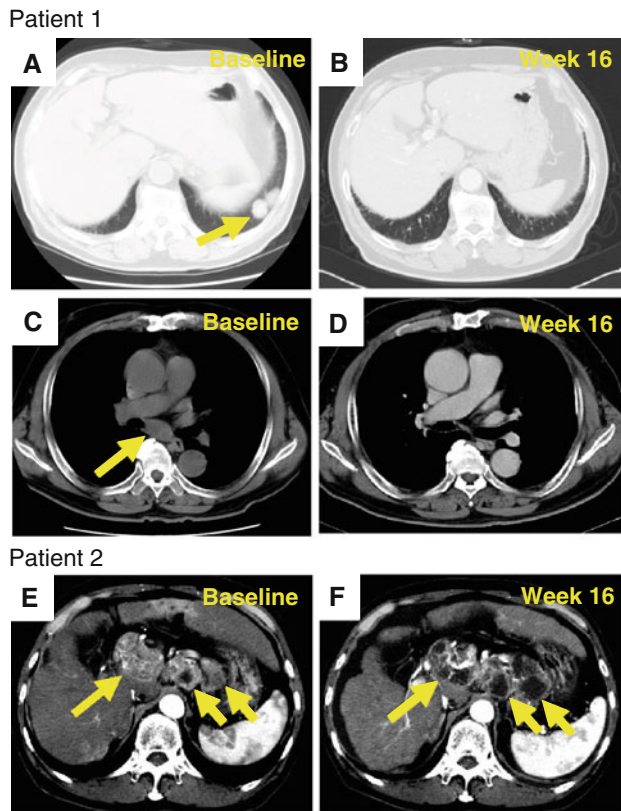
Computed tomography images of responding lesions from patient 1, who achieved a complete response. Metastatic lesions in the lung (a) and lymph node (c) disappeared after four cycles (16 weeks) of TSU-68 treatment (b, d). Representative computed tomography images of a tumor showing necrosis in patient 2. Before treatment, several abdominal lymph node metastases were apparent (e). After four cycles of treatment (16 weeks), the lesions demonstrated a lack of enhancement and markedly lower attenuation, consistent with tumor necrosis (f)
